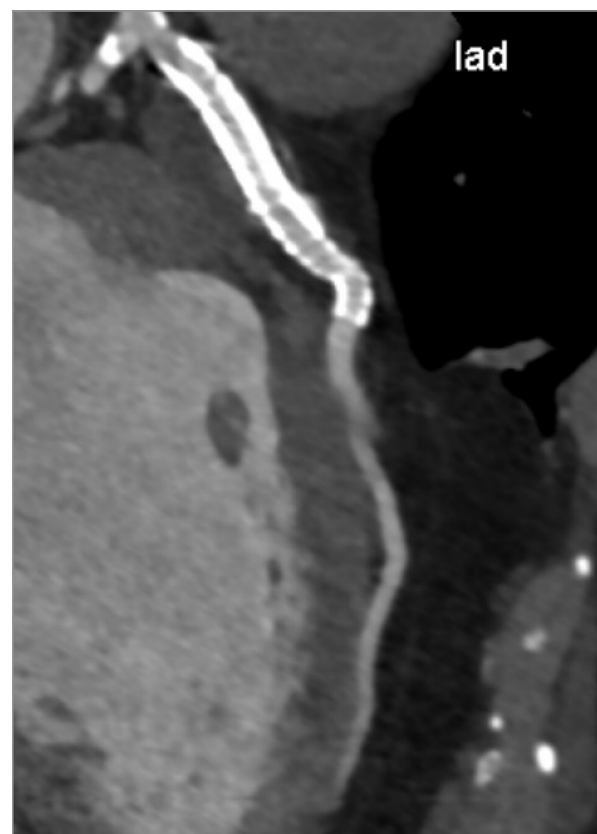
Postprocedural coronary computed tomography angiography outlines the widely patent stent in the left anterior descending coronary artery (LAD) and sealed-off aneurysm.
